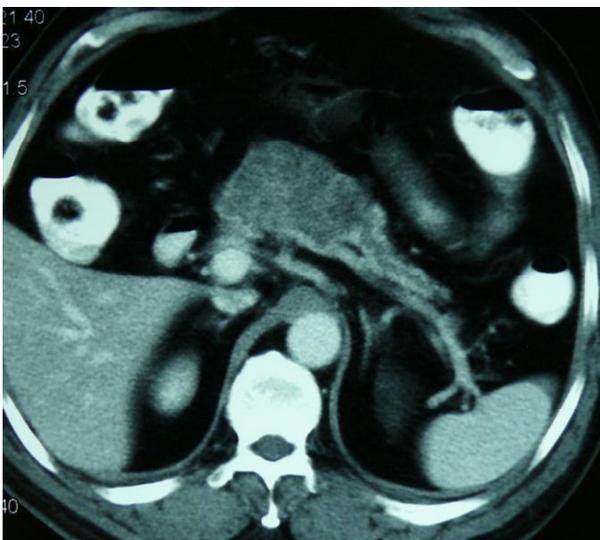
Computed tomography of the abdomen showed a cystic mass with enhancing walls located in the head-body part of the pancreas.
